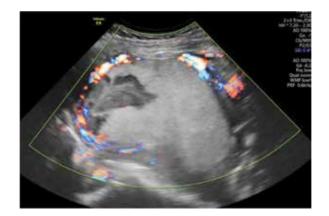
Ultrasound color Doppler image of a case of placenta increta diagnosed in the early second trimester of pregnancy, associated with fetal demise. The surgical termination of pregnancy was performed under laparoscopic guidance, with no complications.
